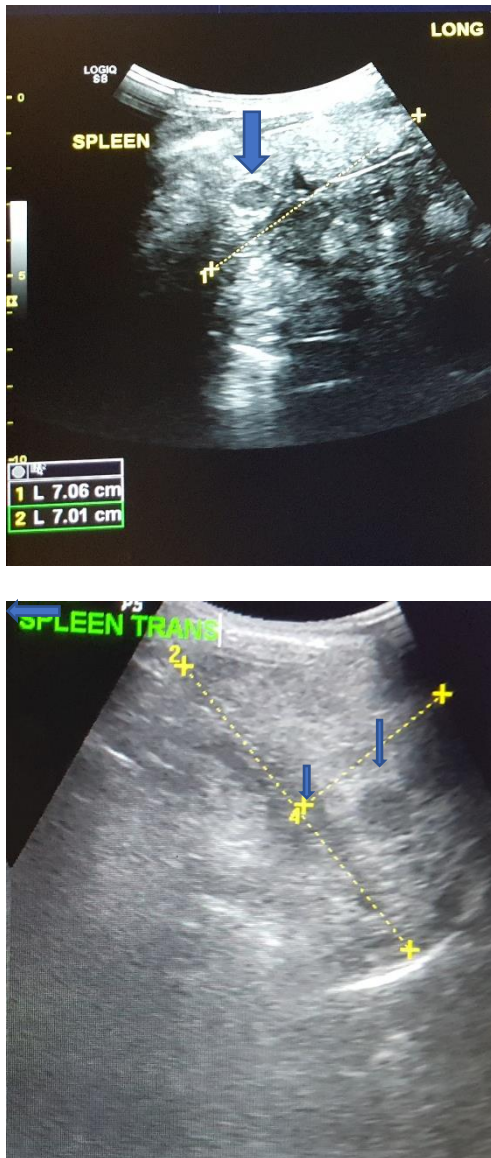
Abdominal ultrasonography showing splenic nodules among SCD patients.
